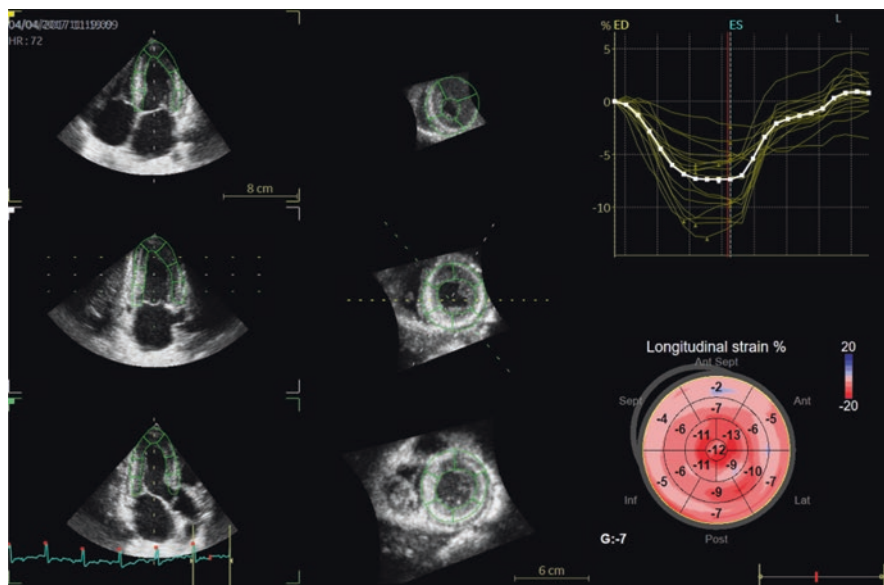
ATTR cardiac amyloidosis. 3D Transthoracic echocardiogram longitudinal strain (LS) analysis. In the upper right corner we can see the strain curves for each segment. In the lower right corner a “bull’s-eye” parametric representation of strain values, with the pattern of apical relative sparing, with characteristic basoapical gradient
